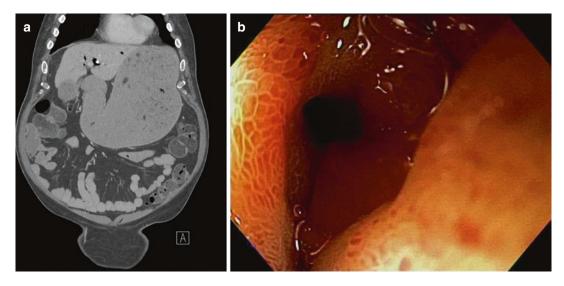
Malignant gastric outlet obstruction. (a) Radiographic appearance of a typical patient with gastric outlet obstruction due to pancreatic malignancy, as seen
